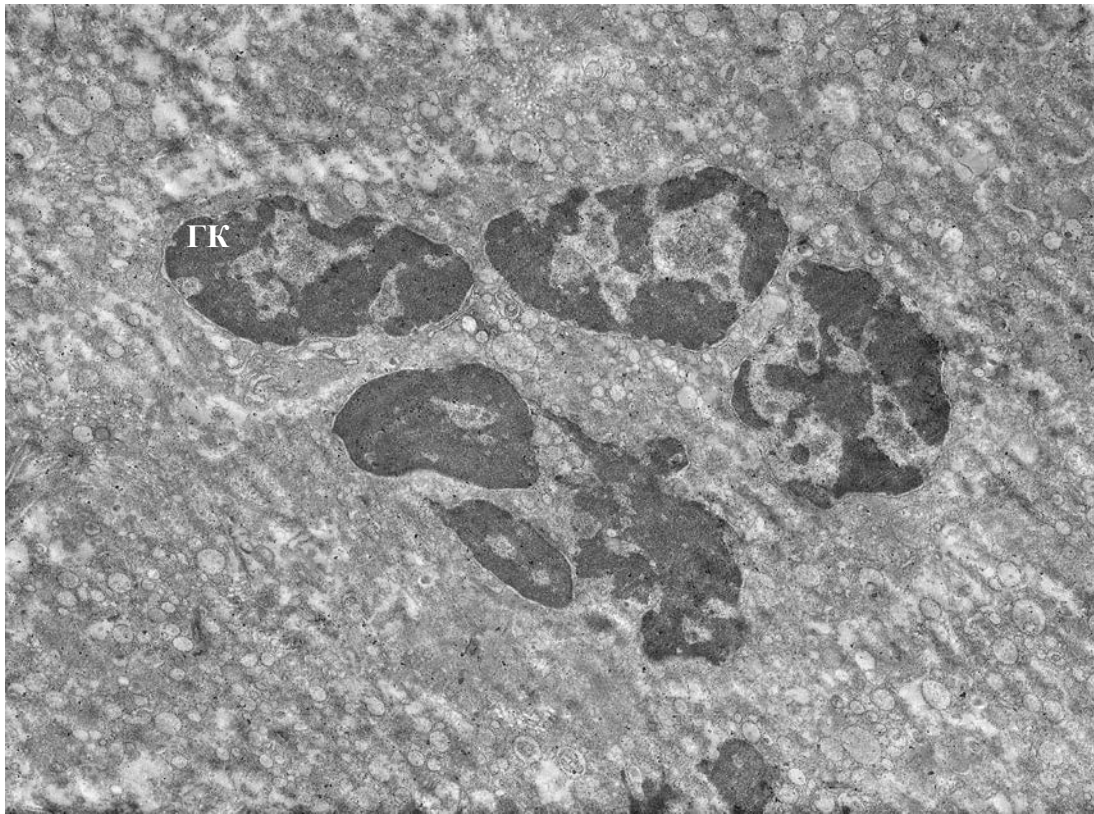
Giant multinucleated cell in the composition of periapical granuloma in patient with secondary chronic granulomatous periodontitis. $\times 4000$.
